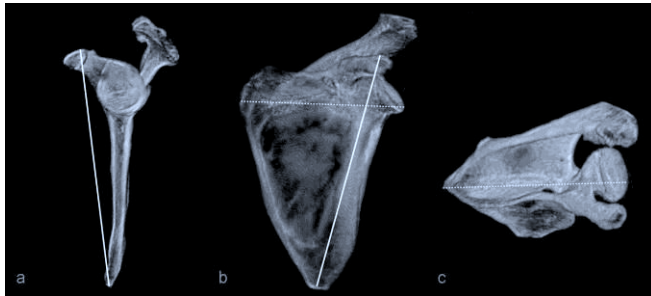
CT scan imaging with volume rendering reconstruction; 1a) LSL in the sagittal plane (continuous grey line); 1b) LSL (continuous grey line) and TSL (dashed grey line) in the coronal plane; 1c) TSL in the axial plane (dashed grey line).
